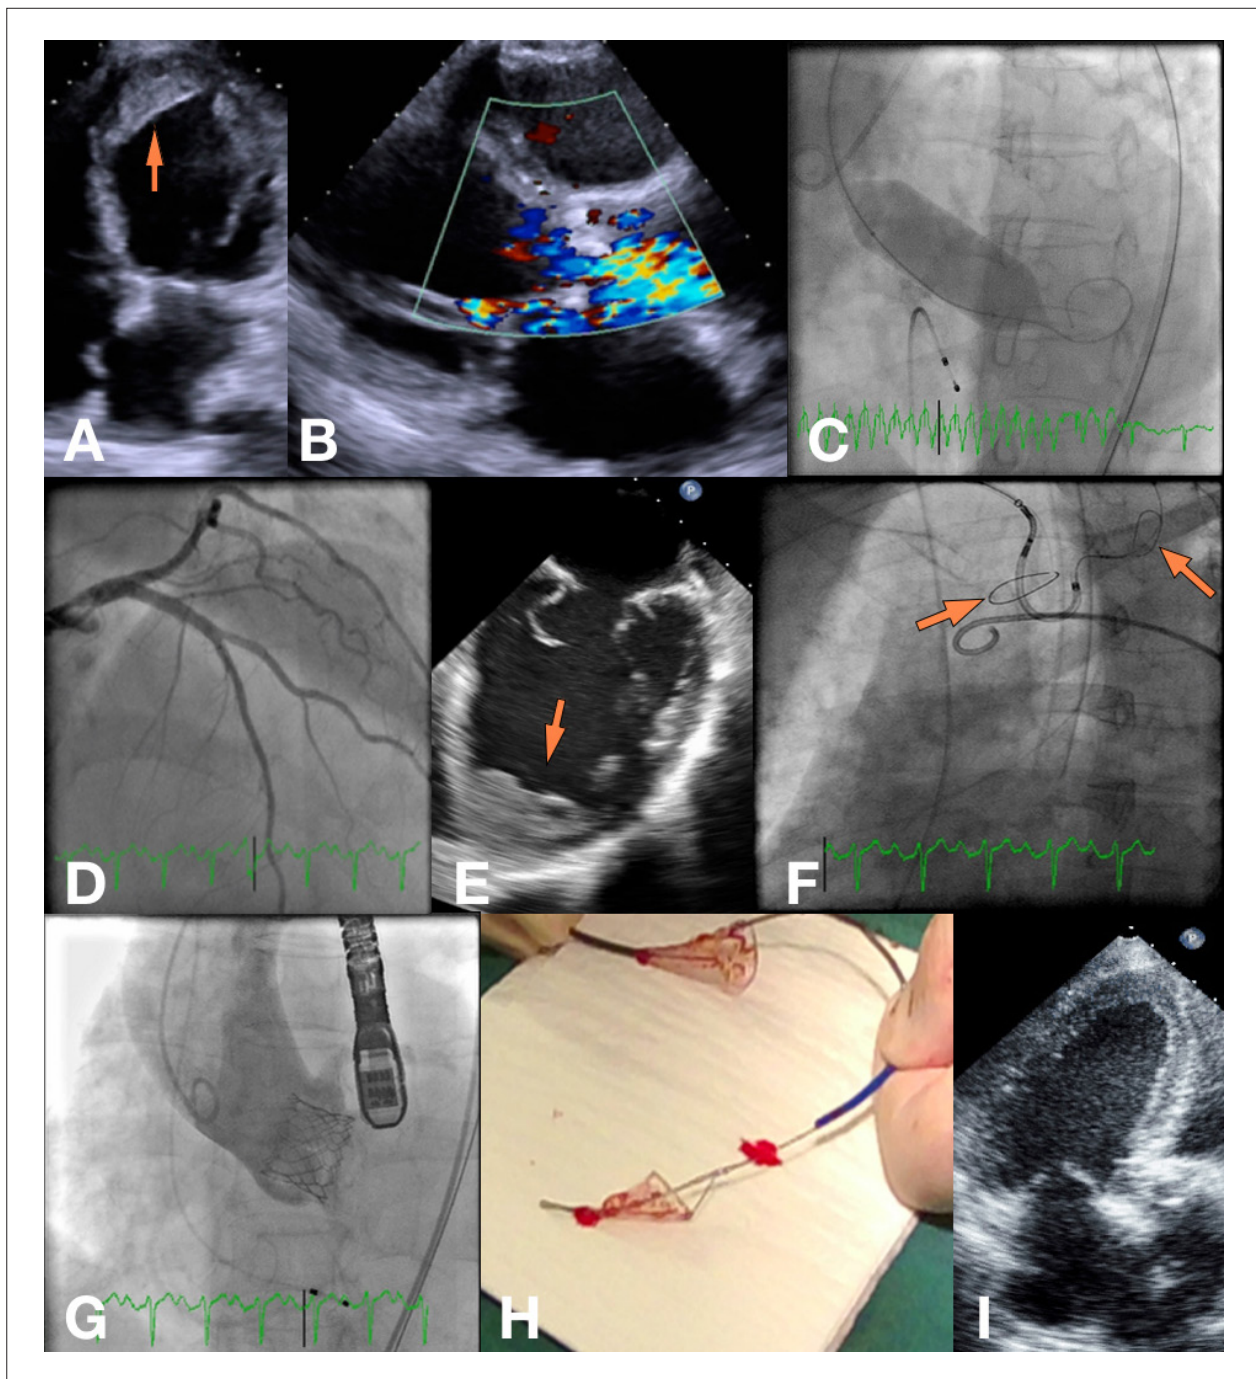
A) Four-chamber view from the admission TTE (arrow: apical thrombus); B) Colour Doppler showing turbulent flow through the aortic valve in parasternal long-axis view; C) Percutaneous aortic balloon valvuloplasty; D) Left coronary angiography; E) TEE showing the large apical thrombus (arrow); F) Embolic protection system deployment (arrows: filters); G) Angiography after TAV implantation; H) Embolic filters with particulate debris; I) Three-chamber view from a TTE, 3-months after the procedure. TTE: transthoracic echocardiography; TEE: transoesophageal echocardiography; TAV: transcatheter aortic valve.
